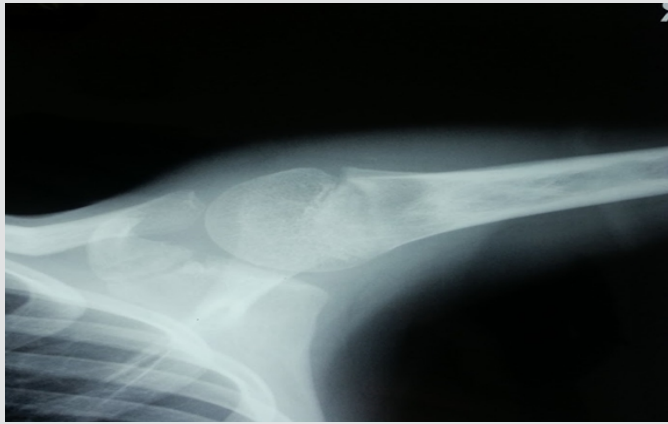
Radiograph showing the lesion getting completely ossified with remodeled bone with good shoulder abduction and intact growth plate at 9 months (3 months after the third injection of liquid absolute alcohol).
